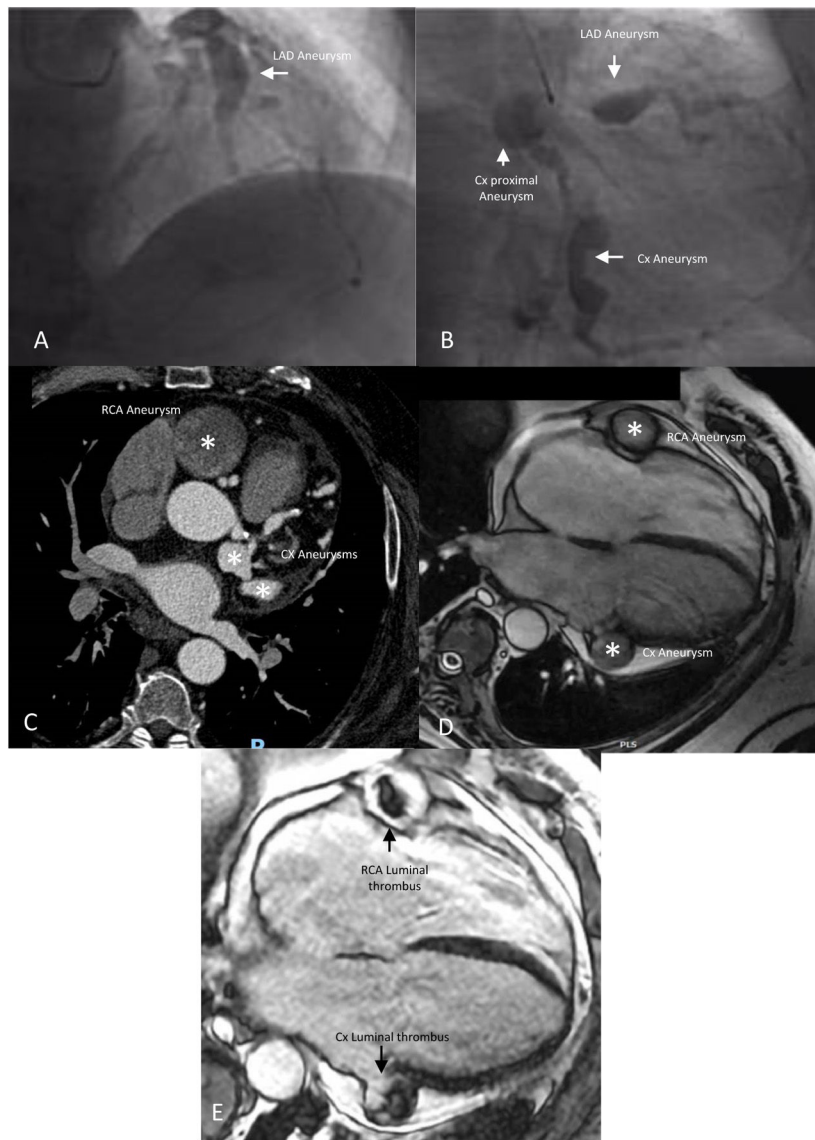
Giant coronary aneurysms seen by invasive coronary angiography (panels A and B), computed tomography coronary angiography (panel C) and cardiac MRI bSSFP cine (panel D) and late gadolinium enhancement (panel E), the latter revealing thrombi in the circumflex and right coronary arteries. bSSFP: balanced Steady-State Free Precession; Cx: circumflex artery; LAD: left anterior descendant artery; RCA: right coronary artery.
